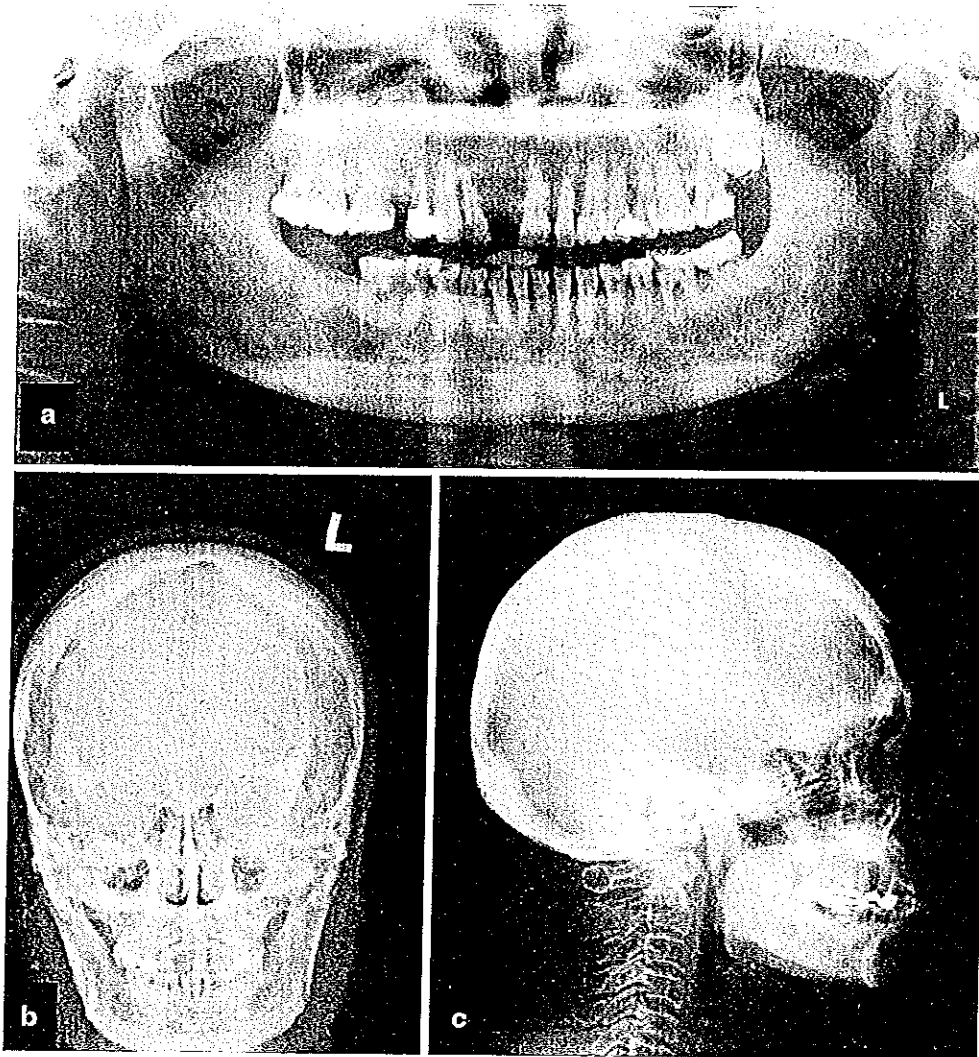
a Panoramic, b lateral skull, and c posteroanterior skull radiographs of the patient's mother. The involved bones show sclerosis and mixed radiolucent and radiopaque patterns
